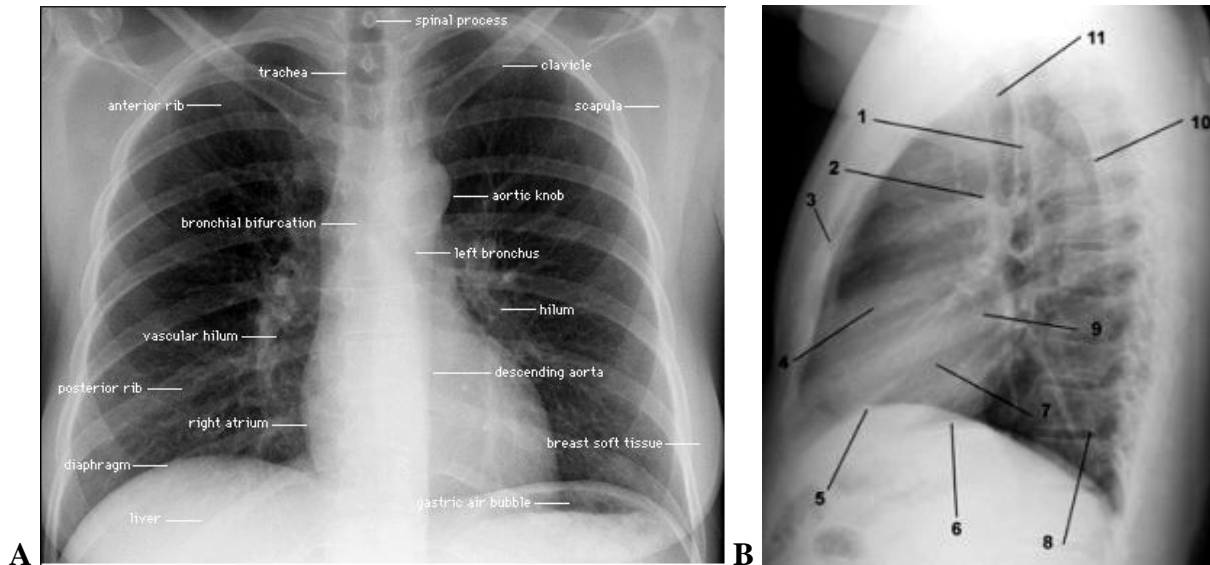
(A) Frontal and (B) lateral radiograph chest indicate marketed of roentgen anatomic structures. (B) 1 — Trachea. 2 — Aortopulmonary window. 3 — Sternum. 4 — Right ventricle. 5 — Right hemidiaphragm. 6 — Left hemidiaphragm. 7 — Left ventricle. 8 — Posterior recess of vertebra. 9 — Left atrium. 10 — Scapula. 11 — Lung field apex
